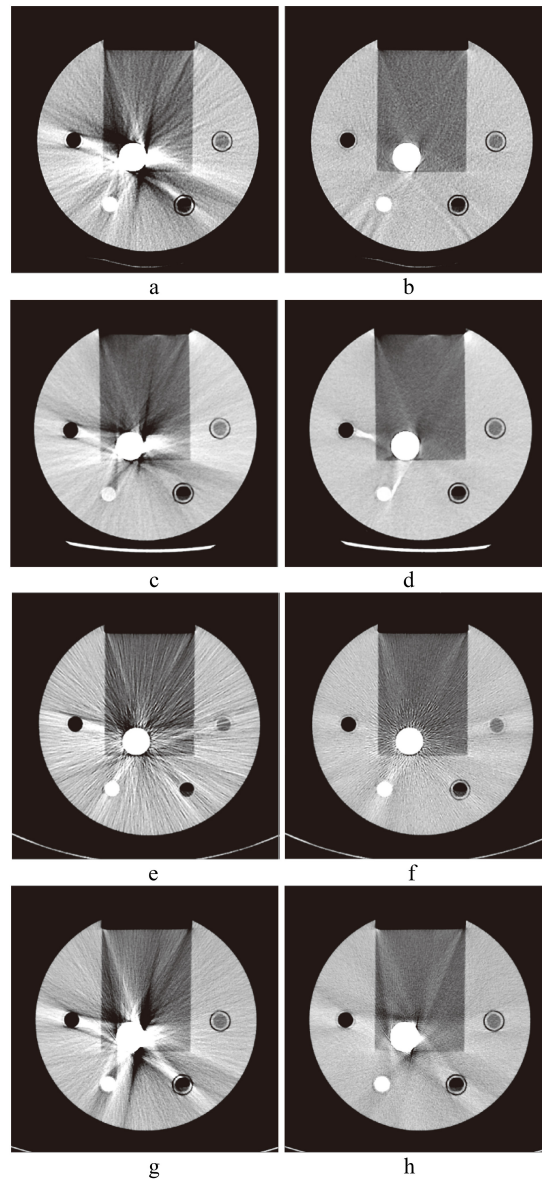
CT images of hip implants. a. Image without SEMAR; b. with SEMAR. c. Image without Smart-MAR; d. with Smart-MAR. e. Image without IMAR; f. with IMAR. g. Image without OMAR; h. with OMAR.
